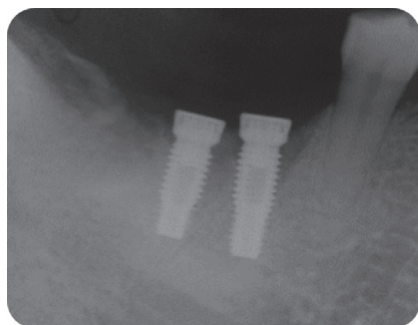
Periapical radiograph when 1st stage surgery of two implants was done three months after the extraction.
